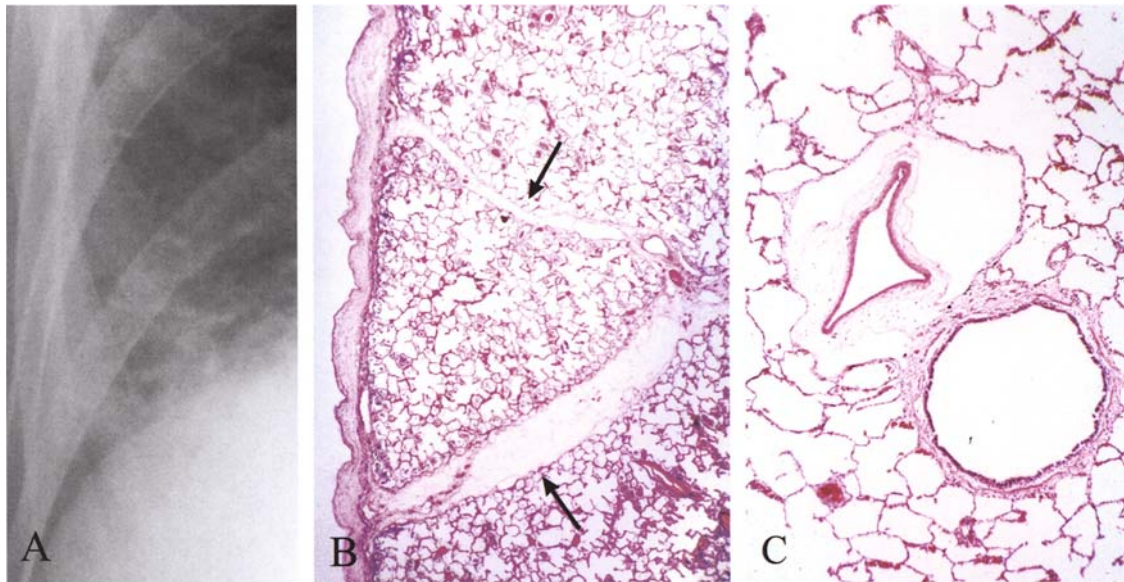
Pulmonary edema. A. Chest x-ray showing Kerley B lines as ill-defined parallel lines extending from the inferolateral pleura. B. Edematous expansion of visceral pleura
